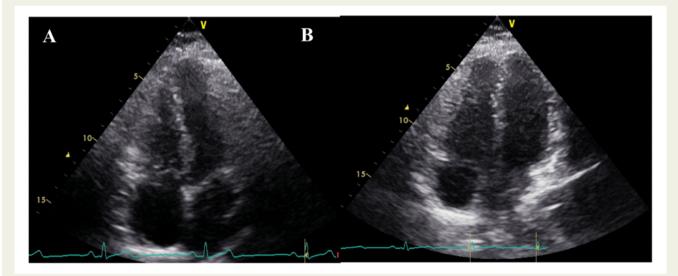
Serial transthoracic echocardiogram. (A) Normal-sized chambers. (B) Mildly dilated right ventricle.
